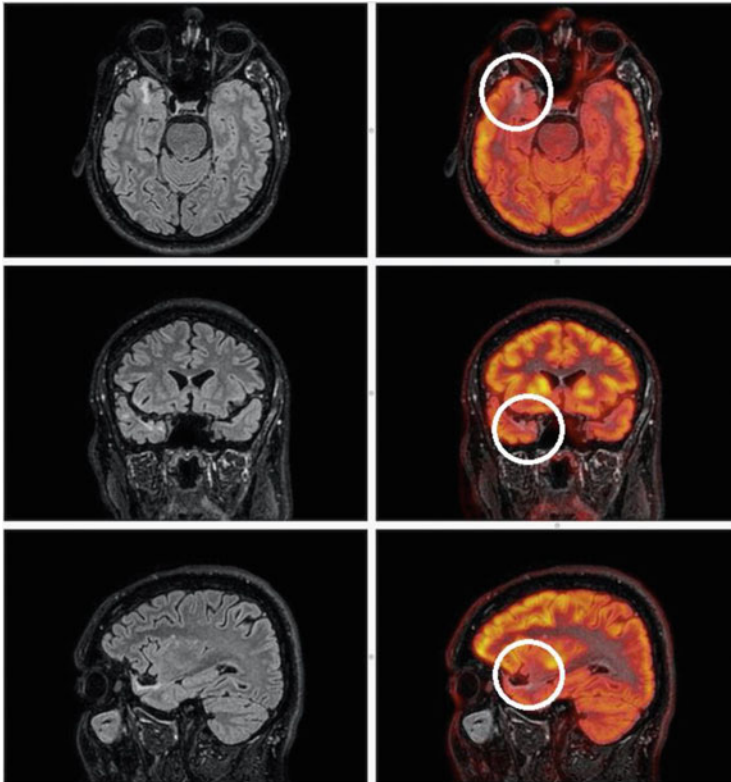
Integration of PET and MRI images—alteration in the temporal lobe
